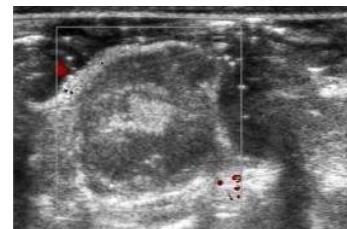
Color Doppler ultrasound results of the tumor in docetaxel microspheres high-dose group
